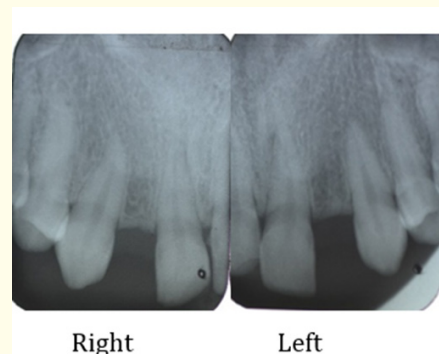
Retroalveolar radiographs.
